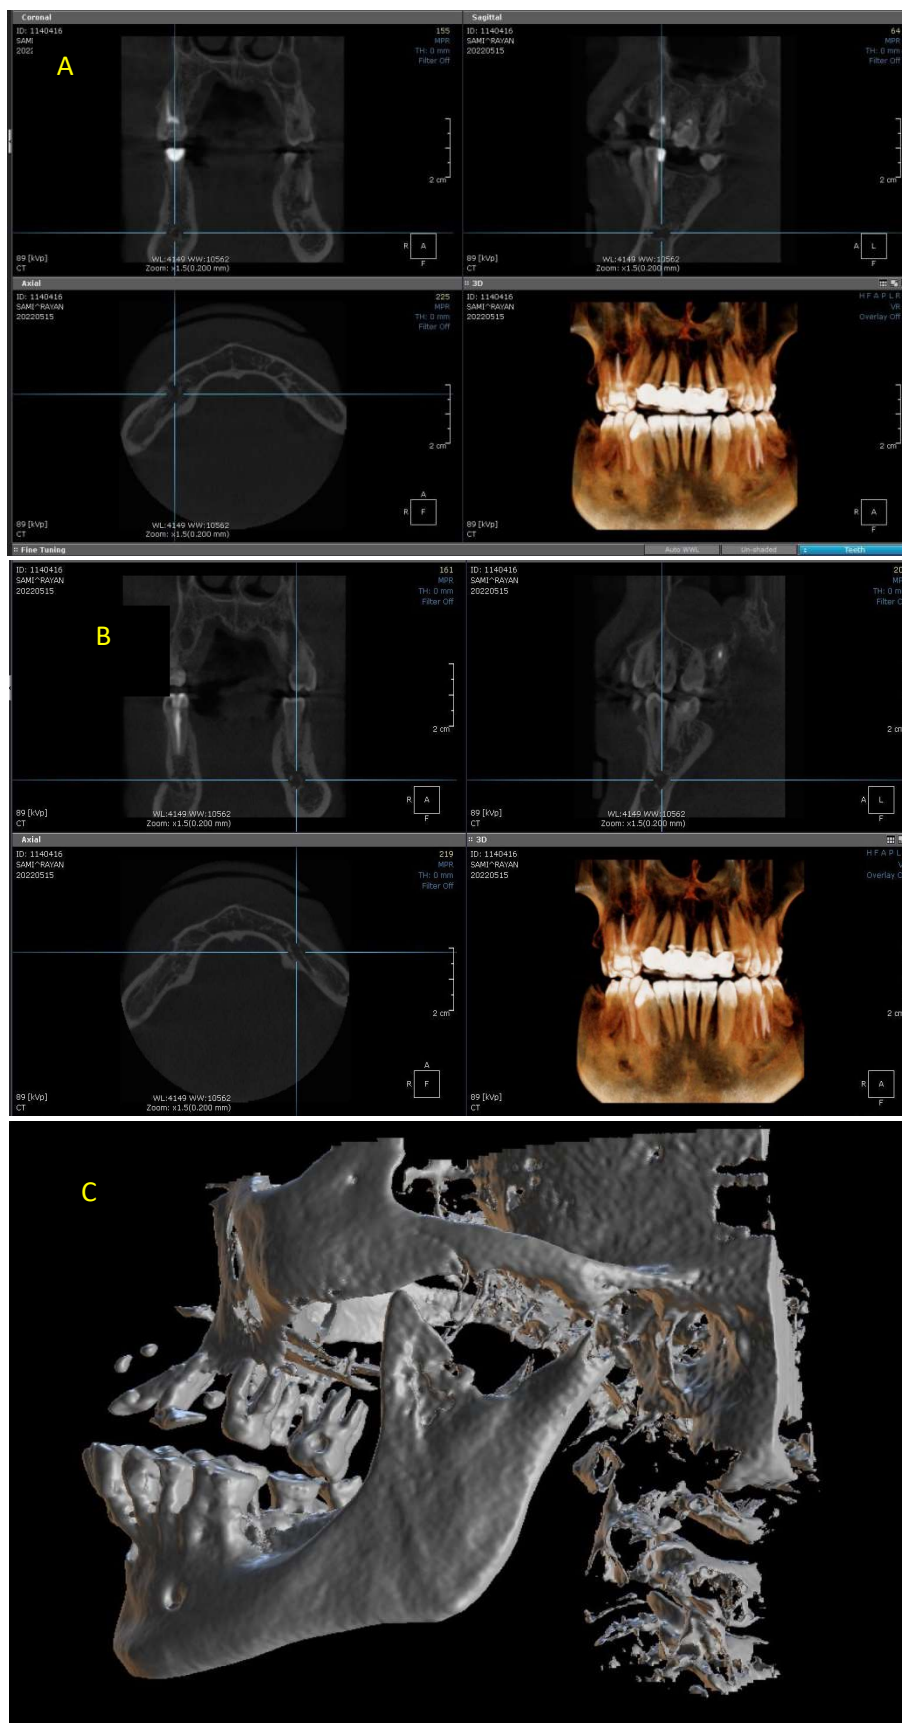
Cone beam computerized tomography Images (A, B, C)
